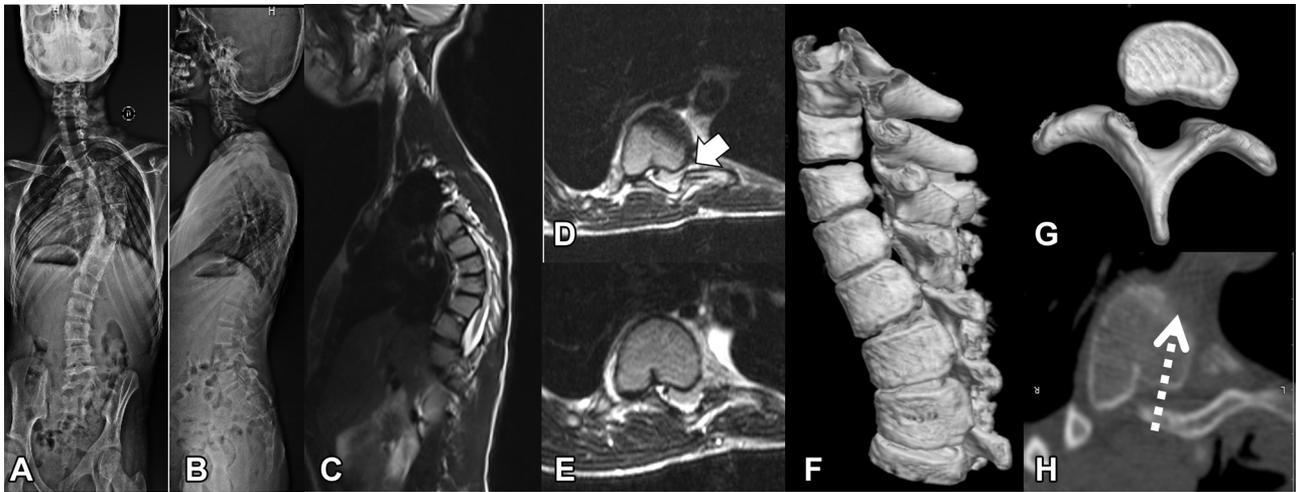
(A, B) Anteroposterior and lateral radiographs showing right proximal thoracic scoliosis. (C) T2 sagittal MRI images showing signal changes in the thoracic cord over the apex of the deformity with absent pedicles. (D, E) Significant spinal canal stenosis (white arrow) is seen. There is a translation in the coronal plane between the vertebral body and the posterior lamina, with cord impingement seen between the vertebral body and the lamina over the concave apex of the curve. (F, G) 3D CT reconstruction of the spine showing absent pedicles with complete dissociation between the anterior and posterior elements at multiple contiguous levels in the thoracic spine. (H) Axial CT images, with the white dotted arrow indicating conventional screw trajectory with likely spinal canal violation.
